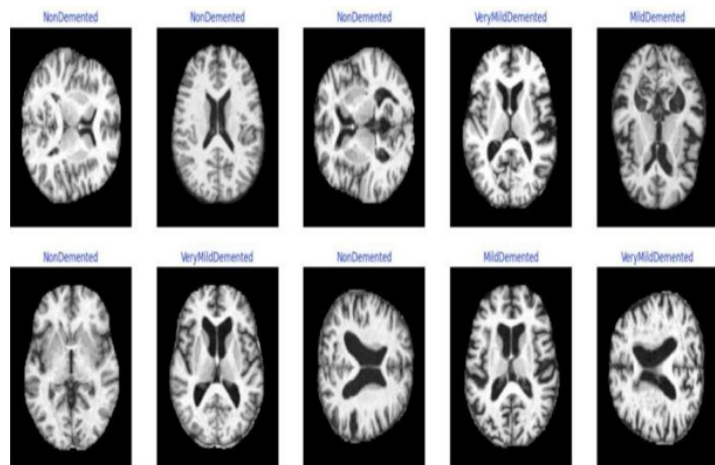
Sample images from the curated MRI dataset used for AD stage classification.
